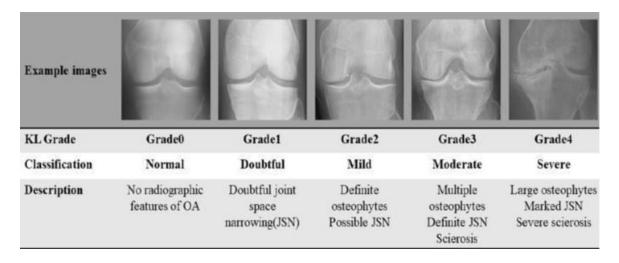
Radiographic classification of OA by Kellgren and Lawrence.
